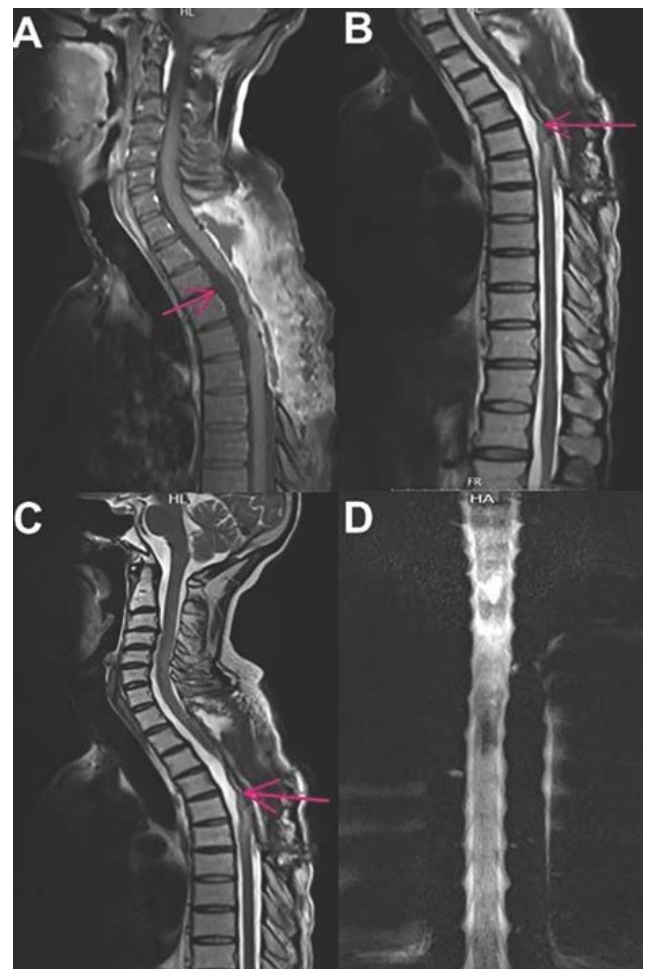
The pre-operation MRI scan of the thoracic spinal cord. Sagittal T1-weighted images show: A solitary (A) hypo-iso intense mass in the intramedullary spinal cord at T3-T6 level (Pink arrow) The lesion (B) showed an avid enhancement with a length of about 8 cm following intravenous gadolinium contrast injection. Sagittal T2-weighted images show: A small (C), sharply well-defined, and hypersignal lesion surrounded by an outer low-signal indicates a cyst due to the degeneration of a tumor cell (white arrow). A fluid-filled cyst (syrinx) within the spinal cord because of a central canal block extending into the cervical cord (Pink arrows). Thoracic myelogram, anteroposterior view: pre-operative myelogram (D) shows a filling defect between T3 and T6 due to an intradural, intramedullary lesion (pink arrows). Exiting nerve roots (green arrows).
